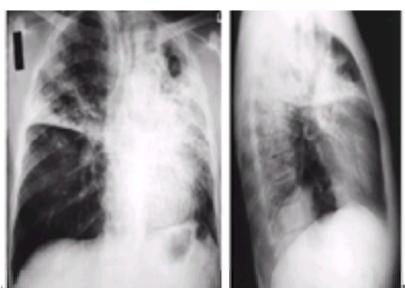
Admission posteroanterior (A) and lateral (B) x-ray films of case 1. Note the volume loss and bilateral upper lobe infiltrates with a cavity in the left upper lobe.
